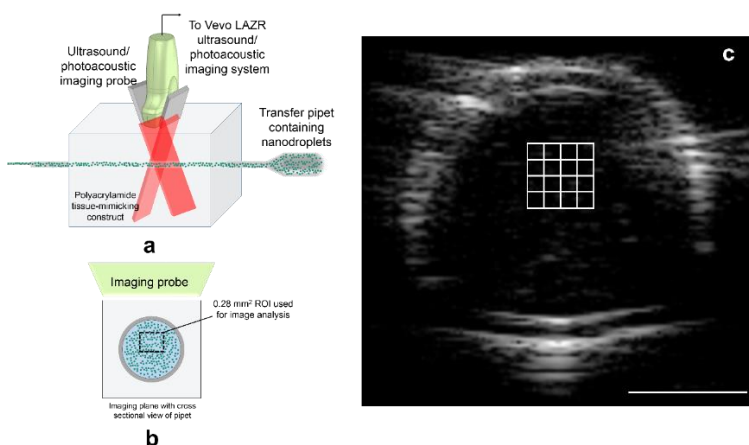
(a) Imaging setup for nanodroplet samples, using a Vevo LAZR dual US/PA imaging system. (b) Depiction of droplets within the pipette in the ultrasound imaging plane. (c) Ultrasound image depicted with the subsectioned ROI used for signal analysis. Scale bar = 2 mm.
